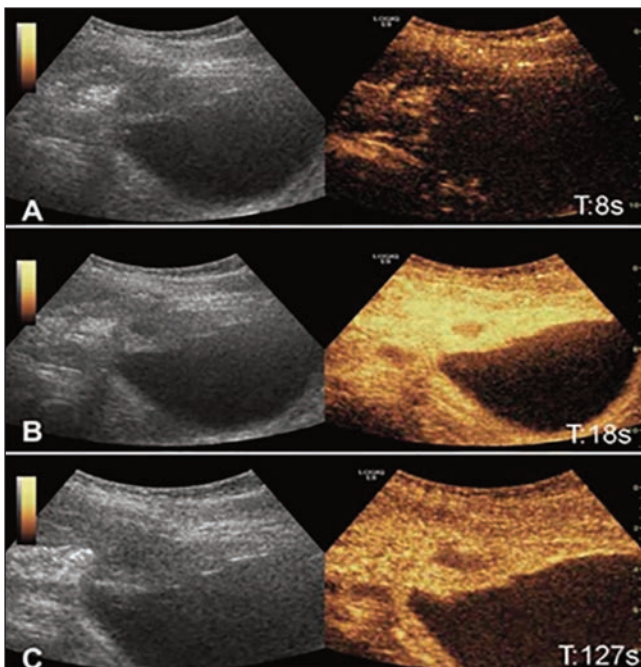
Contrast-enhanced ultrasonography (CEUS) examination showed that A) After the injection of the contrast agent, the perfusion of the ultrasound contrast agent began at 8 seconds, slightly earlier than the surrounding normal tissues (bladder wall, cervix). B) The peak was reached at the 18th second, the lesion showed slightly uneven high enhancement, the boundary was not clear, and a few perfusion defect areas were seen inside. C) After 2 minutes and 7 seconds, the contrast agent began to subside, the lesions showed a slightly higher enhancement, and the contrast agent subsided slowly.
